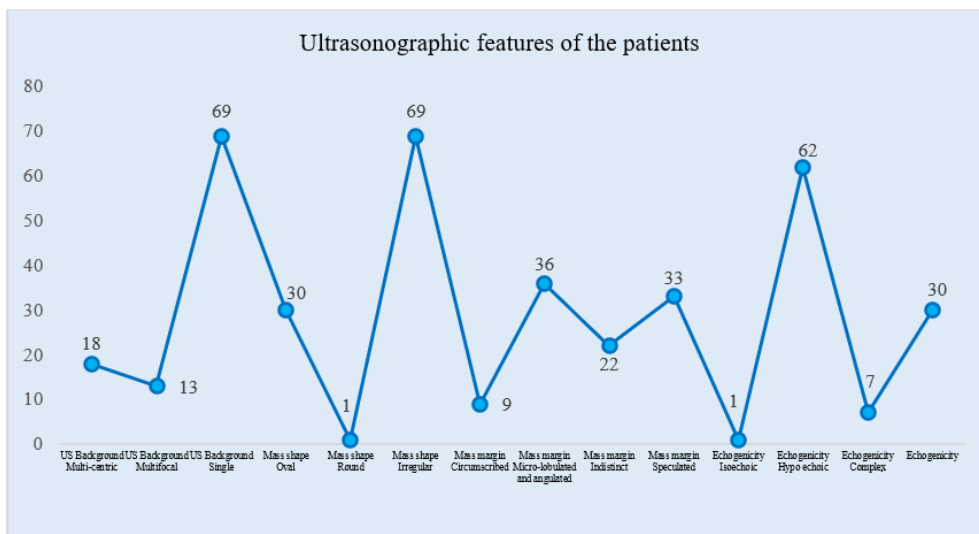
Line chart showed ultrasonographic features wise patients (N=67)
